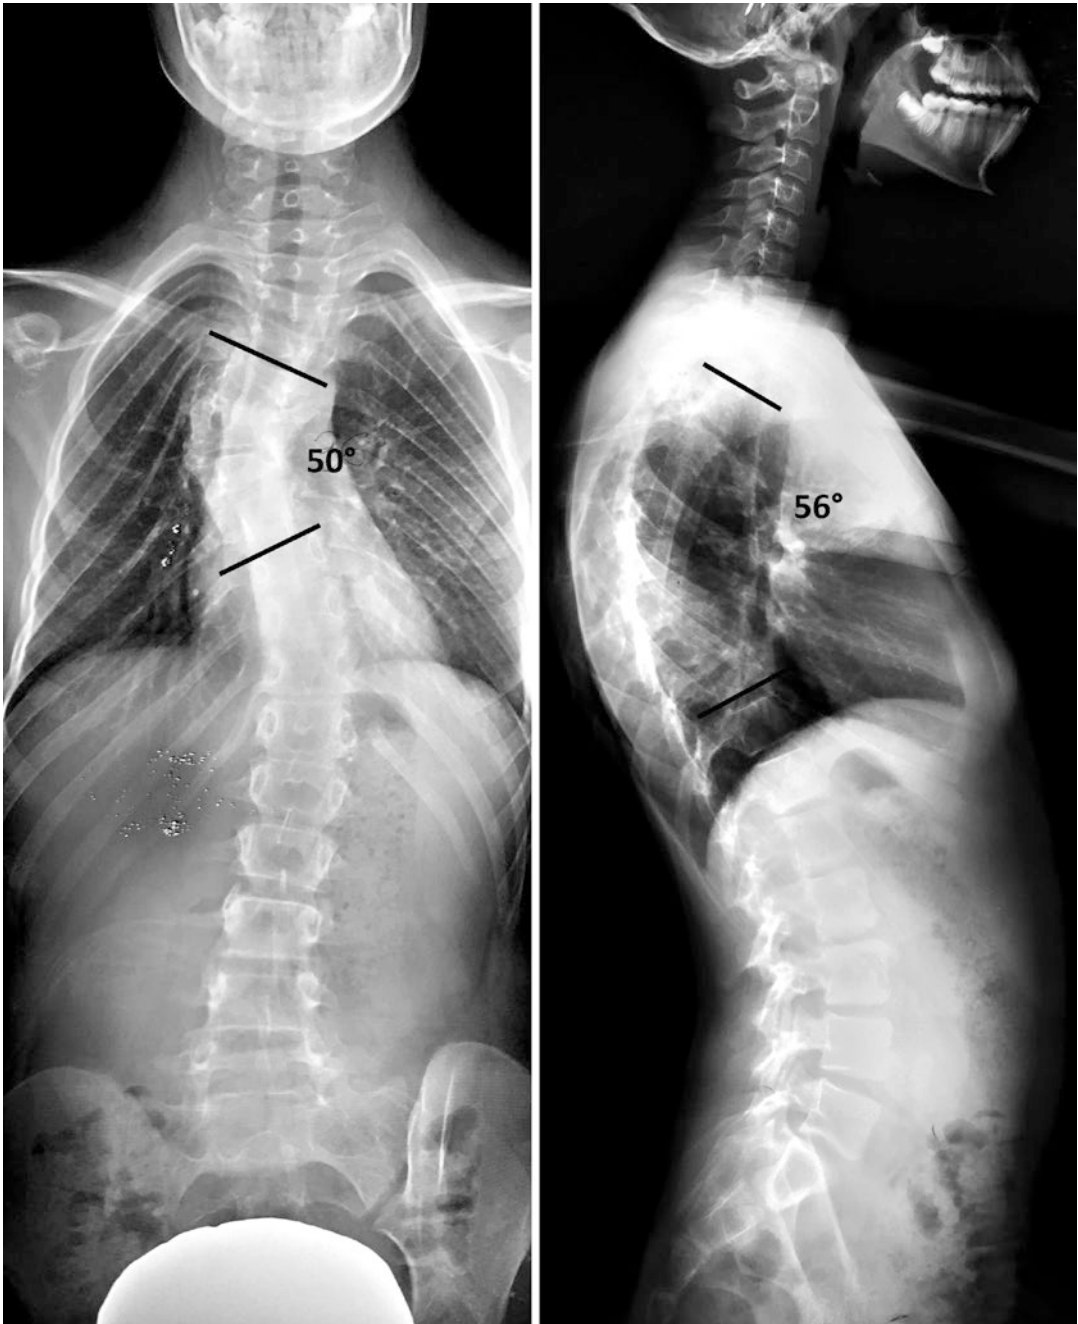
Standing whole spine radiographs in NF1 patient 12 years old, showing sharp angular right-sided kyphoscoliosis: dystrophic curves have always surgical indication and the conservative treatment is contraindicated
